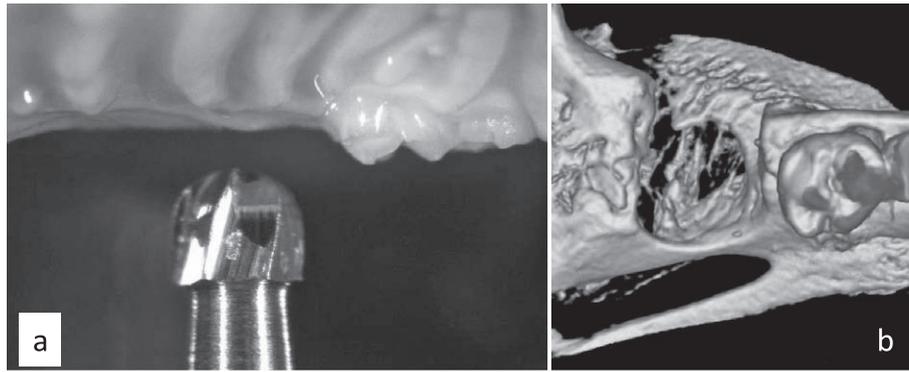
Macroscopic and CT-images
